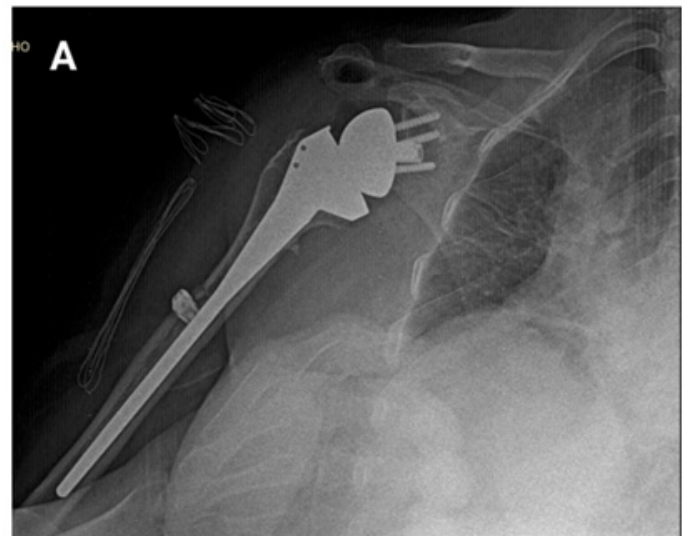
follow-up radiograph of the right shoulder after reverse total prosthesis replacement with a long stem. Stabilization of the metadiaphyseal humerus fracture with osteosynthesis material (isoelastic supercable) is observed. A. Anteroposterior radiograph.
